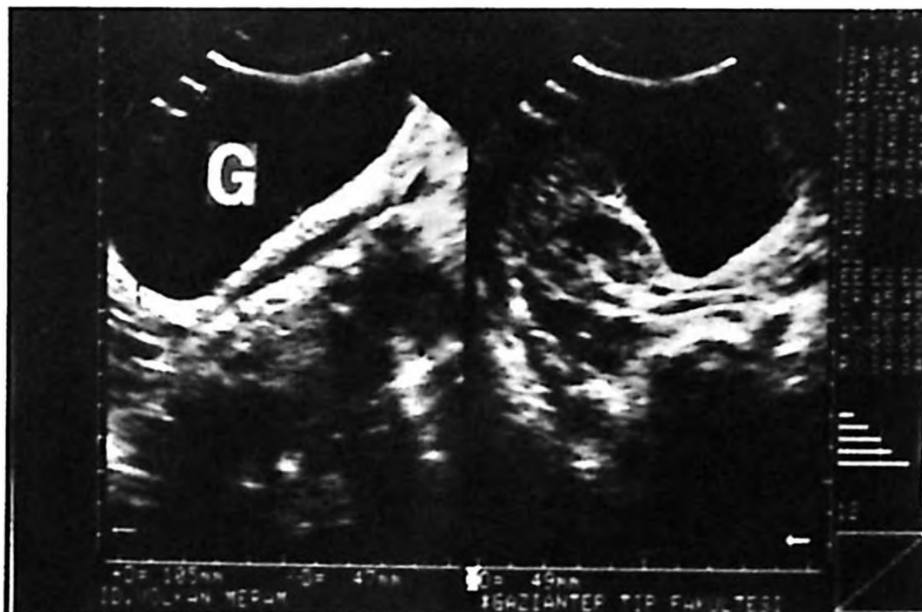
The appearance of hydropic gallbladder in ultrasonography. G: gallbladder.
